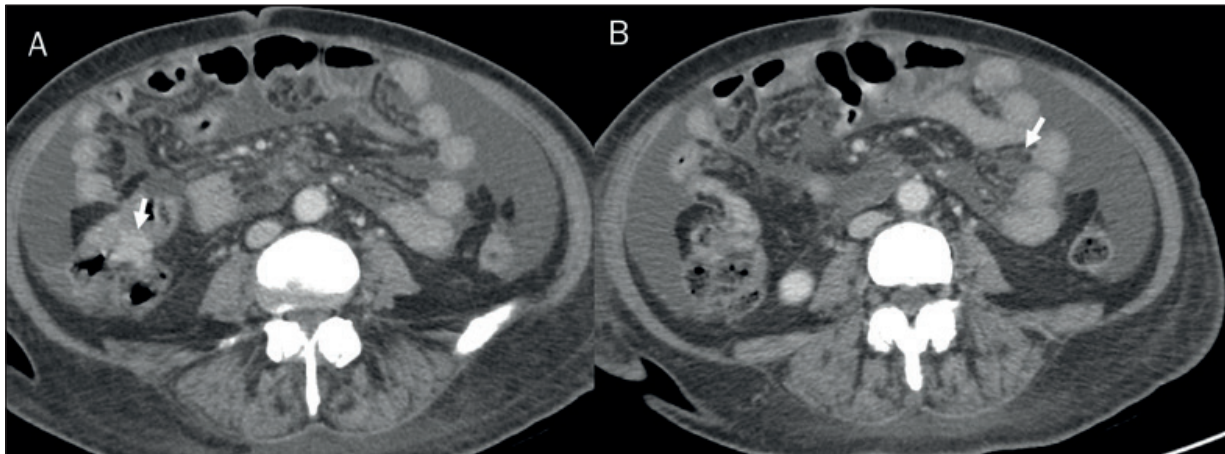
Patient with Right Colon Cancer assessed on contrast CT study. In A, the arrow shows the primary lesion and in B disseminate peritoneal involvement.
